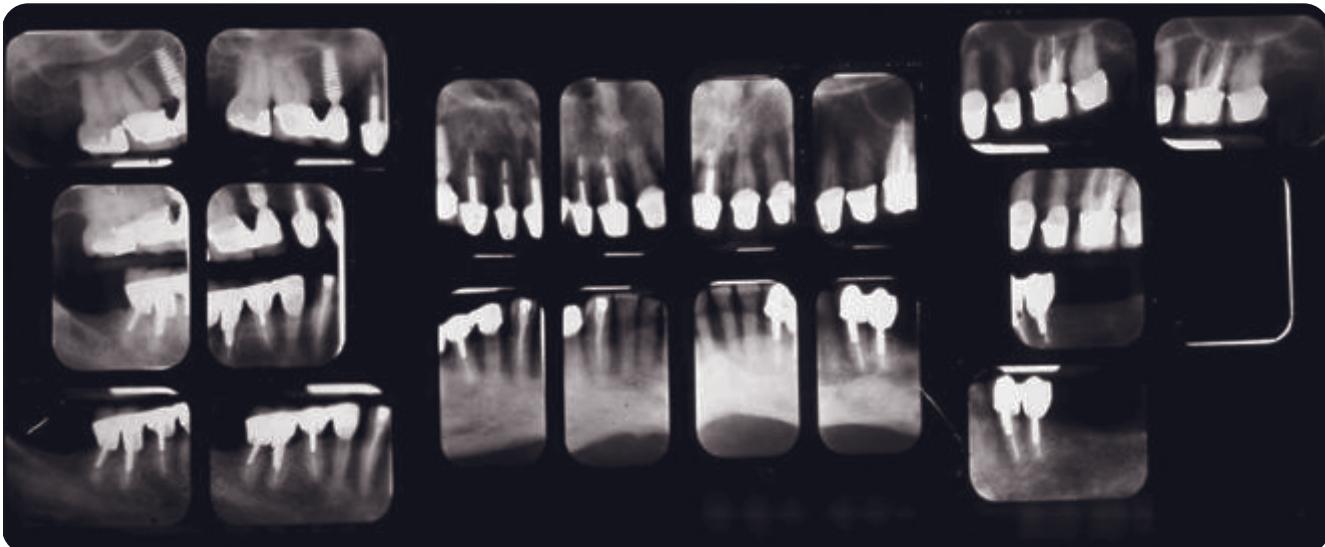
Pretreatment radiographs suggesting many guarded teeth due to large posts and cores.
